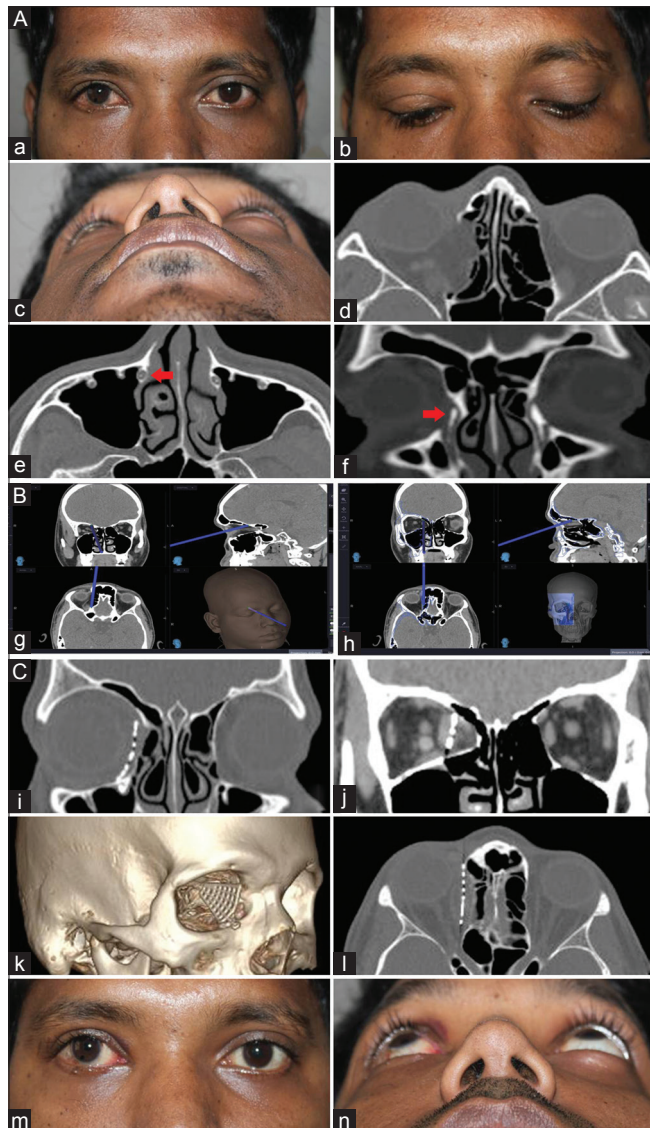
(A) (a-c) Clinical picture showing right enophthalmos. Patient had a ptosis correction and intraocular surgery done elsewhere. (d) CT scan showing right medial wall fracture. (e and f) CTDCG showing intact lacrimal drainage system (red arrows). (B) (g) Navigation pointer used to assess the extent of the fracture. (h) Pointer placed over the implant shows correct placement of implant coinciding with the mirrored image (blue). (C) (i-n) Postop CT scan and clinical picture showing the implant position and improvement in enophthalmos
